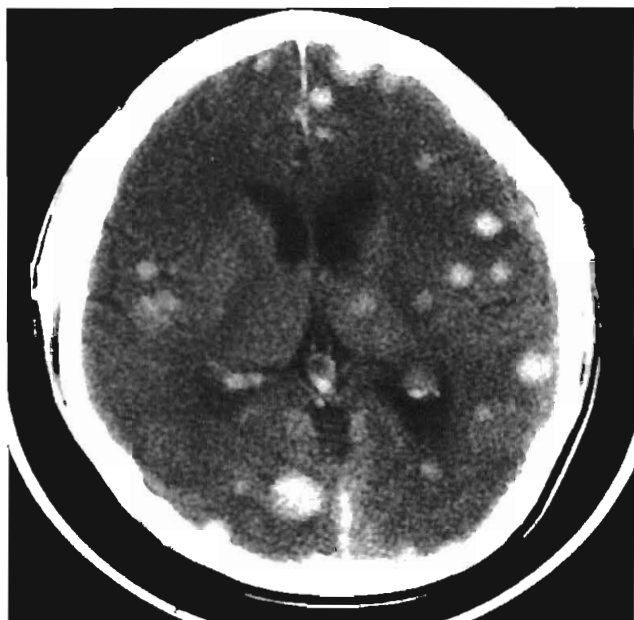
Intracranial metastatic disease. Axial contrast-enhanced CT scan of the head reveals multiple enhancing nodules throughout the gray and white matter structures, consistent with metastatic disease.
